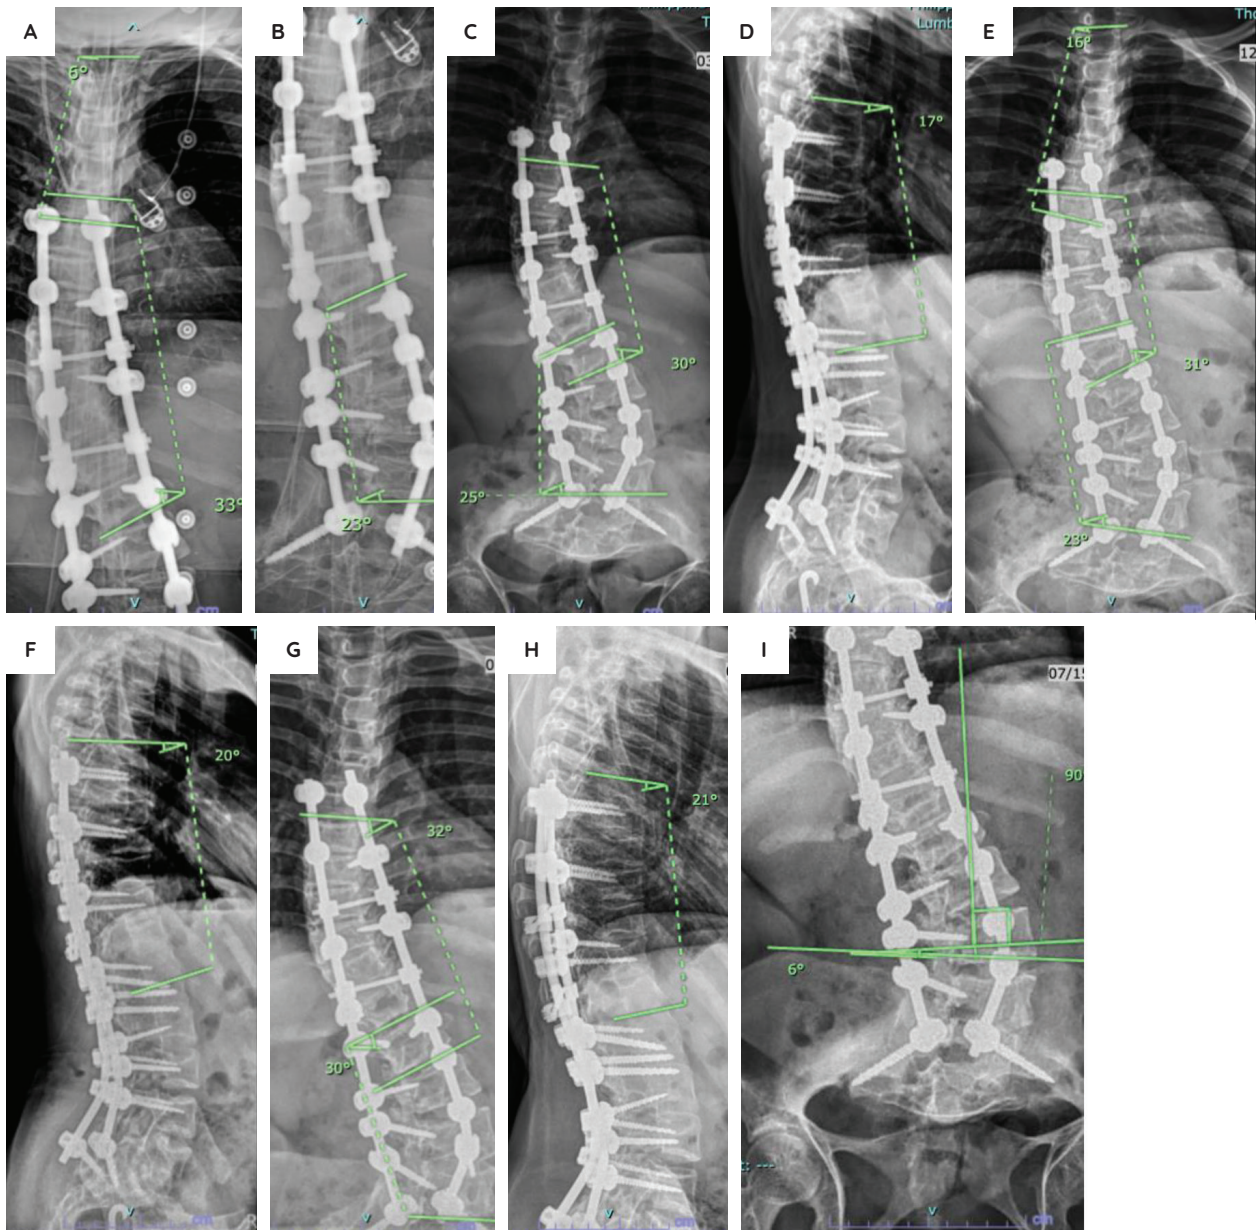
Patient A postoperative radiographs. Postoperative AP xrays of patient A (A and B). Standing AP and lateral xrays of Patient A two months postoperatively, with intact fixation and no screw pullouts (C and D). Standing AP and lateral xrays of Patient A six months postoperatively showing loss of correction of the thoracic curve of 1 degree and kyphosis by 3 degrees but the latter still within normal limits (10–40 degrees) (E and F). Standing AP and lateral xrays of Patient A one year postoperatively showing total loss of correction of the thoracic curve of 2 degrees and kyphosis by 1 degree but the latter still within normal limits (G and H). Signs of fusion are also seen. Measurement of pelvic obliquity one year postoperatively within normal limits (<10 degrees) (I).
